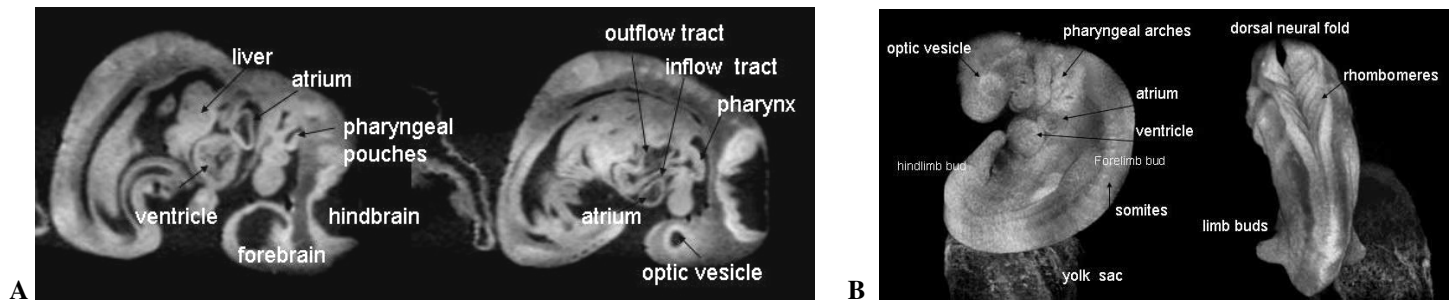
Carnegie stage 13 3D MRI data set with anatomic identification. A. 2D sagittal views (ImageJ); B. 3D projection (Volocity).
